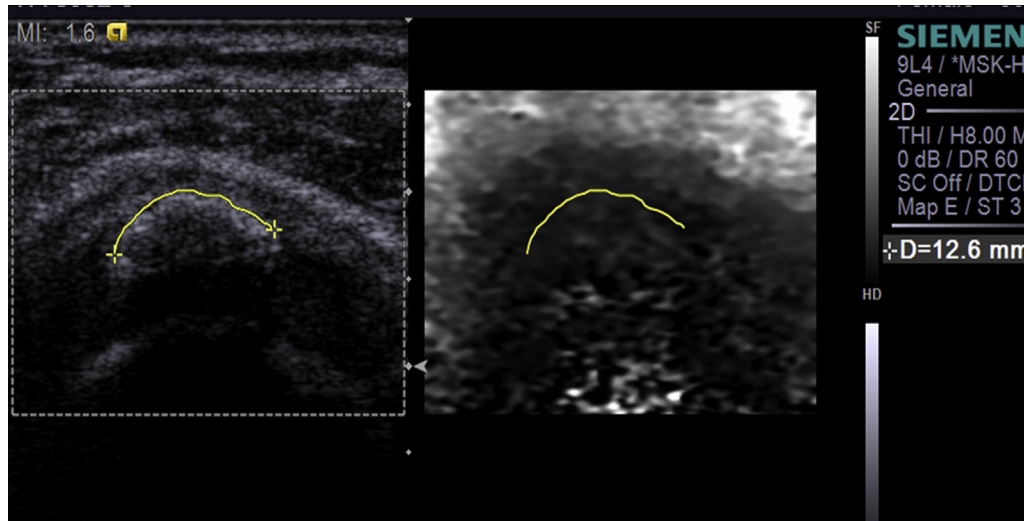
Imaging studies from a 56-year-old woman who complained of right shoulder pain for 6 months. Gray-scale ultrasound (US) showed arc-type calcific (curved line) tendinosis within the rotator cuff, and elastography exhibited a dark pattern (curved line). The patient received US-guided repeated puncture, and had pain relief 6 months later.
